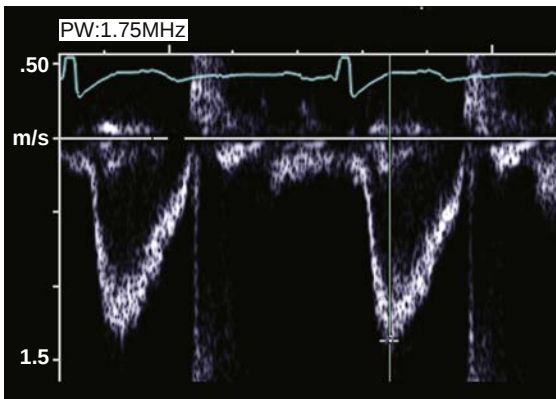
Pulsed Doppler velocity recording. The spectral display of the pulsed wave (PW) Doppler signal is shown with the baseline shifted and velocity scale adjusted to avoid aliasing and to use the full vertical axis to improve measurement accuracy; for example, the signal fits but fills the graphical display. The horizontal time scale is 100 mm/s, which is standard for most Doppler recordings.
